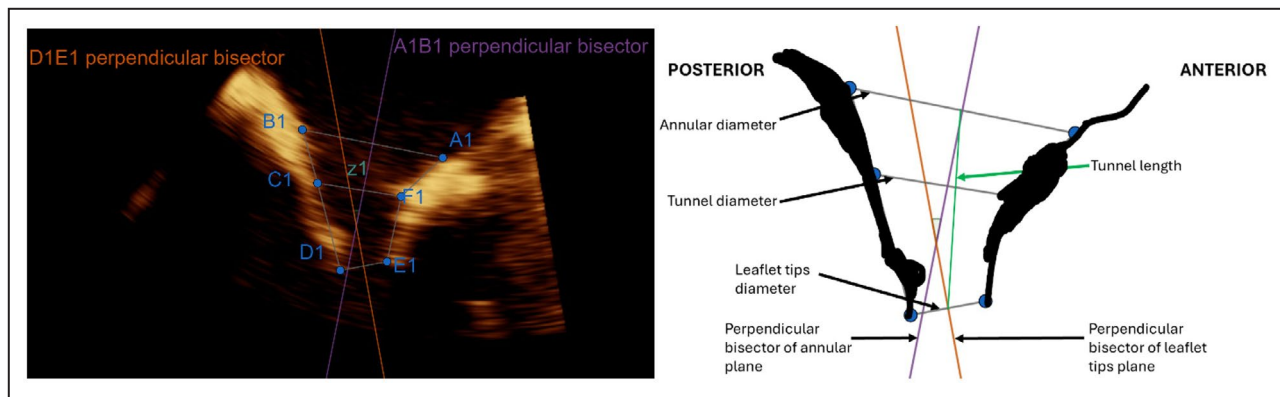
Anteroposterior echocardiographic view.
